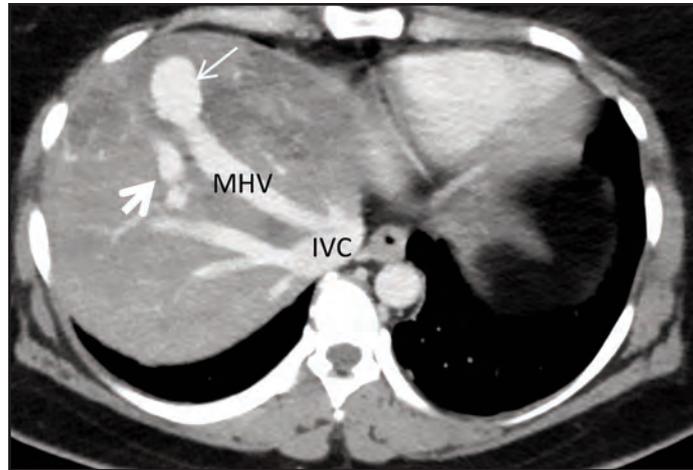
CT Axial view. Presence of the shunt (thin arrow) connecting the MHV and the anterior sectoral branch of right portal vein (thick arrow). MHV - middle hepatic vein, IVC - inferior vena cava
